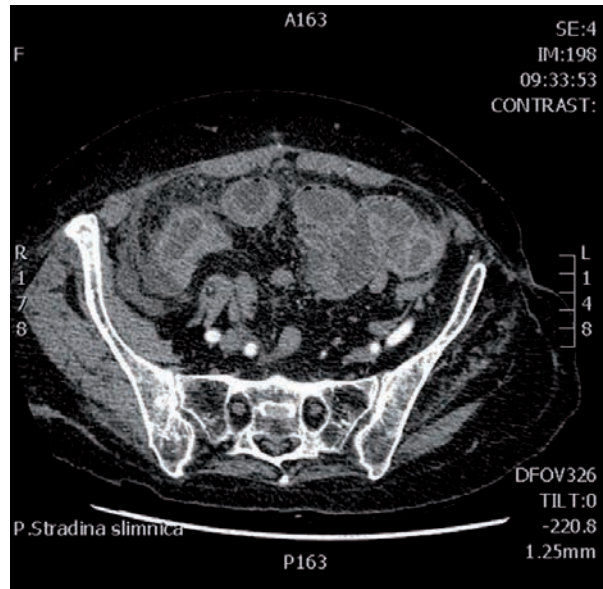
Abdominal computed tomography findings before the operation. Note the markedly distended intestinal loops.
